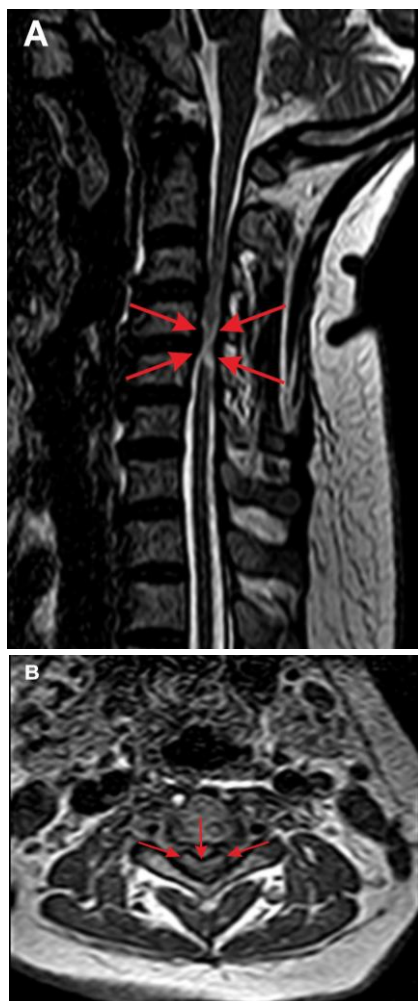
Non-contrast cervical MRI showing cervical myelopathy. Figure 1A shows a T2 sagittal view of the cervical spinal cord, in which hyperintensity (red arrows) can be seen, indicating cervical myelopathy. The C3–C5 spinal cord is also compressed. Figure 1B shows an axial view of the cervical spinal cord. At the C4–C5 level, hyperintensity (red arrows) can be seen mostly in the anterior region indicating cervical myelopathy
